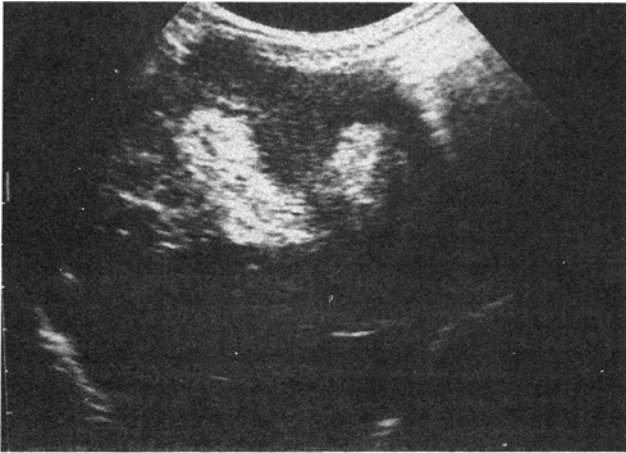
Transverse ultrasonogram of liver shows thick hyperechoic bands in the line of portal tracts.
